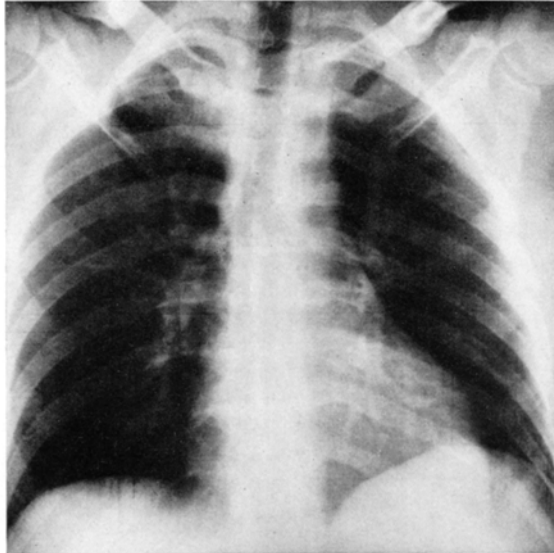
a and b. Chest X-ray pictures of the patient. a Immediately after admission, normal cardiopulmonary status
